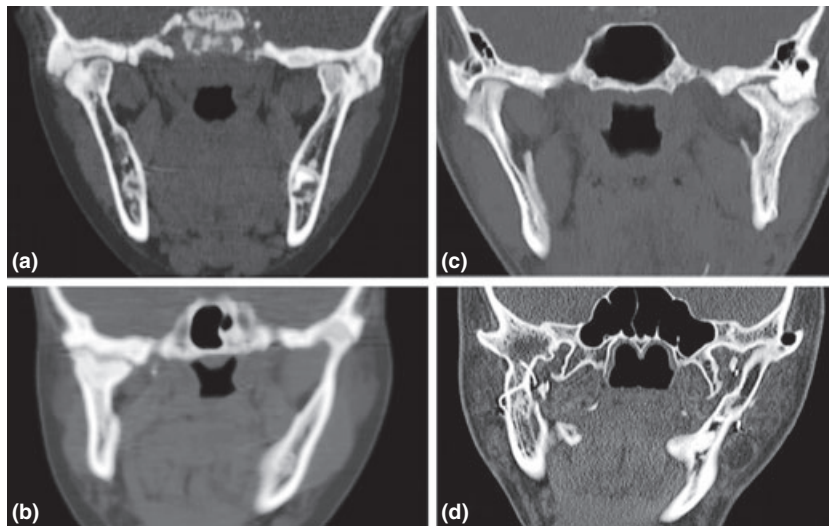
CT of present case series. A, B: CT of cases with bilateral TMJ ankylosis and bilateral BMC oriented mesio-laterally with lateral head ankylosed. C, D: CT of cases with bilateral TMJ ankylosis and left BMC oriented mesio-laterally with lateral head ankylosed. (CT, Computed Tomogram; TMJ, Tempromandibular Joint; BMC, Bifid Mandibular Condyle).
